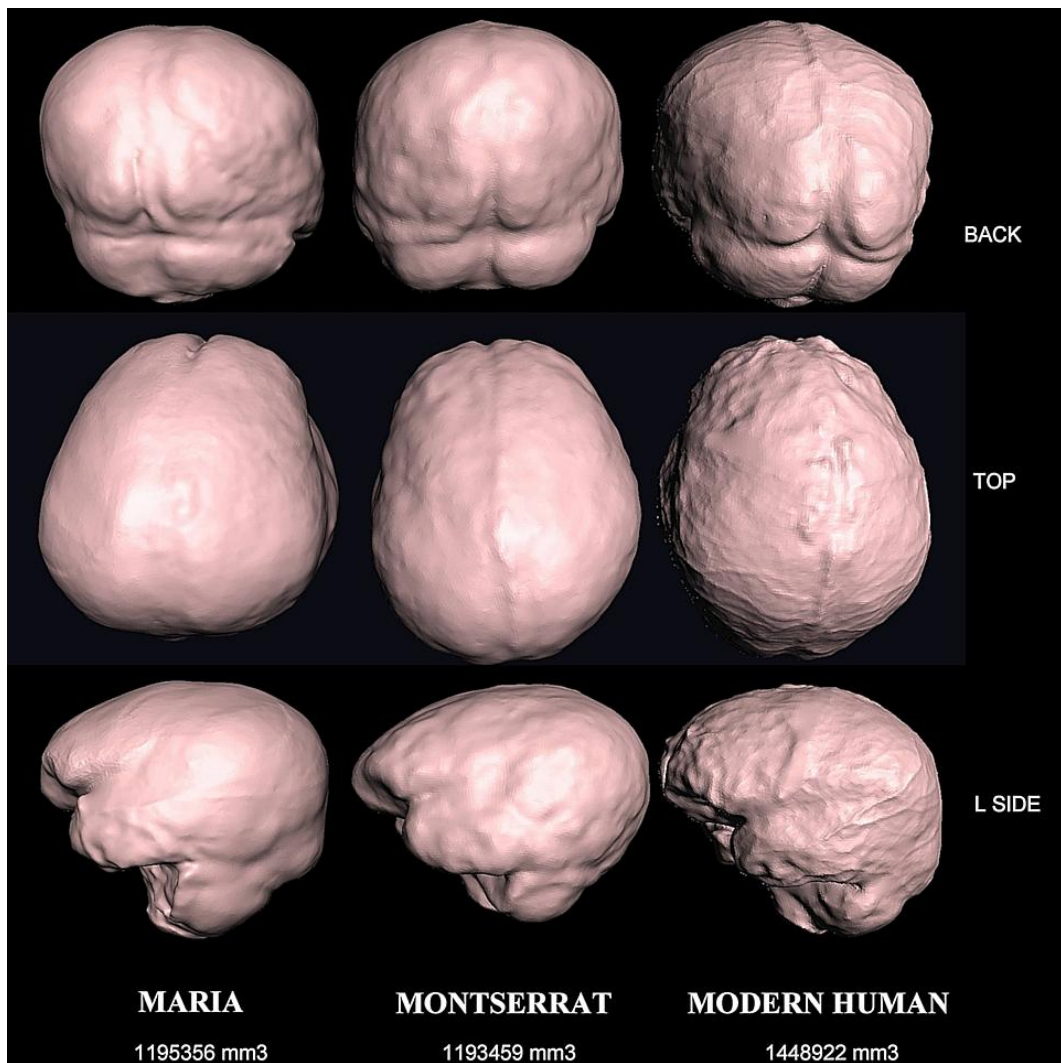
Comparison of 3D virtual cranial endocasts created from CT datasets of Maria (*left*), Montserrat (*middle*) and modern human (*right*). Note the direct volume measurement from the 3D models showed the cranial capacity of Maria and Montserrat were similar and smaller than normal human.
